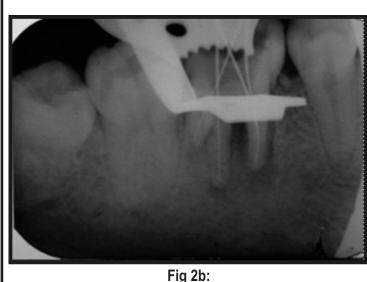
Working length IOPA radiograph w.r.t 46
